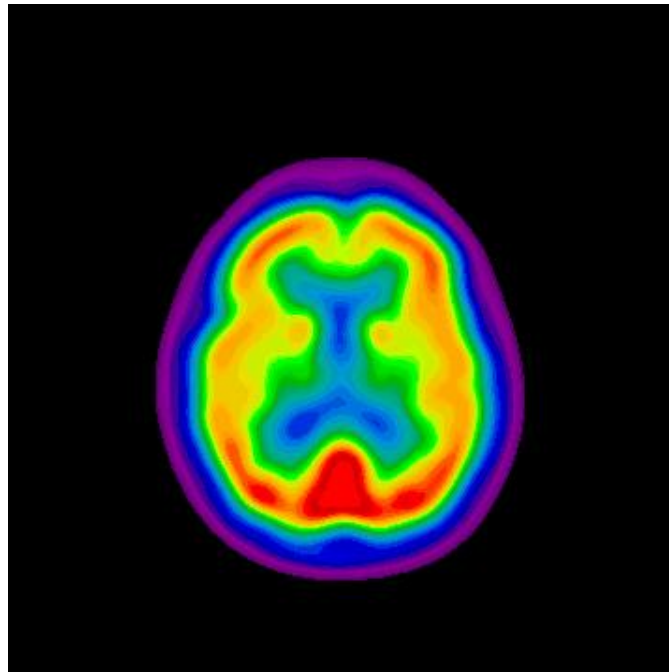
Healthy Brain - FDG PET: axial orientation.
